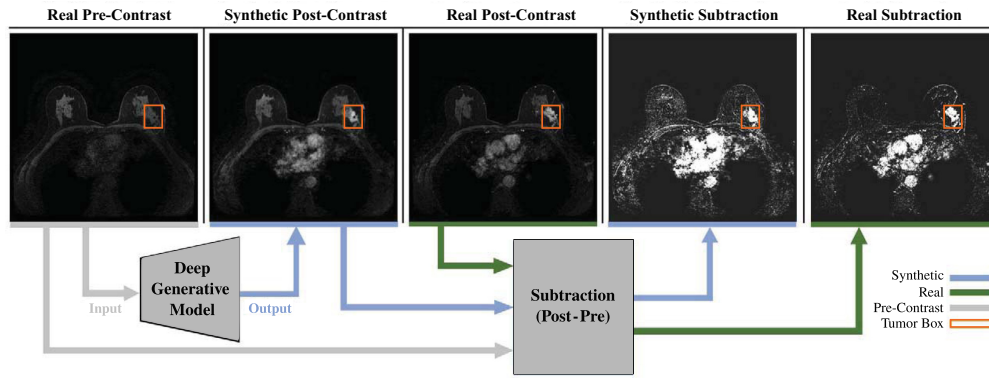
Overview of the pre- to post-contrast DCE-MRI synthesis using deep generative models, thereby localizing the contrast-enhanced tumor. Extending single sequence to multi-sequence DCE-MRI image generation further allows the characterization of tumors based on their temporal patterns of contrast agent uptake. The resulting synthetic images can be added as training data for downstream tasks (e.g., tumor segmentation), but, as shown, they can also be utilized to compute subtraction images commonly used in clinical settings for the diagnosis and treatment of breast cancer.
